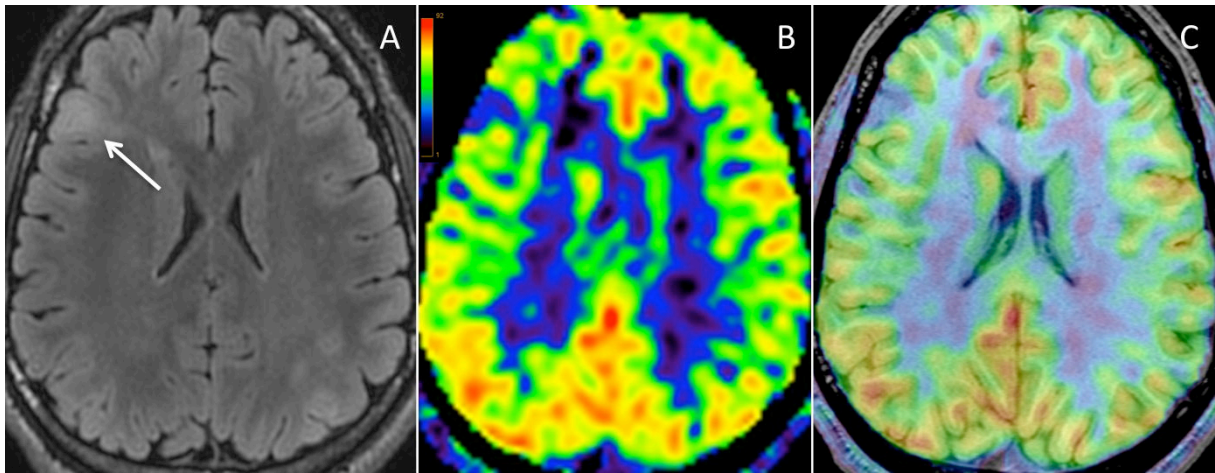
Imagerie par marquage de spin artériel à 3Tesla : Dysplasie corticale focale fronto-operculaire droite visible sur une coupe axiale FLAIR (A). Cartographie du débit sanguin cérébral (DSC) montrant une baisse du DSC du cortex en regard de la lésion, mieux identifiable sur l'image recalée sur l'anatomie en 3DT1 (C) que sur l'image native (B).
